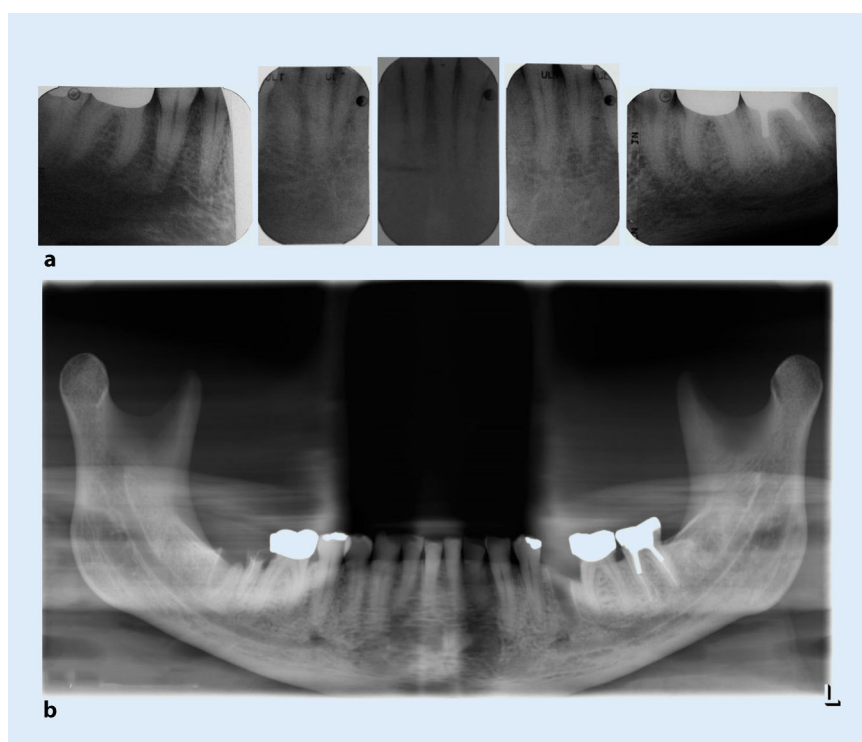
▲ a Antemortem intraoral x-rays from July 2012. b Post-mortem panoramic radiograph performed in December 2016
